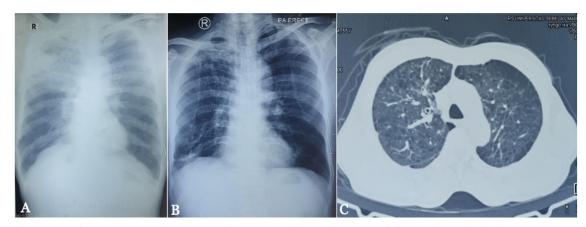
Chest X-ray and computed tomography (CT) scan of the patient. (A) Chest X-ray of patient on December 2022 suggesting a lung mass. Chest X-ray (B) and CT scan (C) evaluations of patient on February 2023 after treatment.
